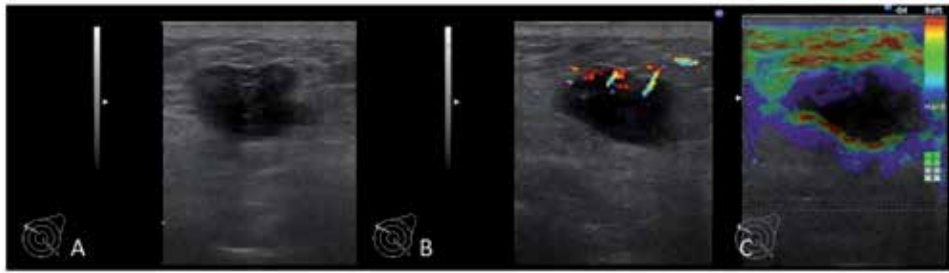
Intensely hypoechoic nodule with partially well-defined, partially ill-defined margins (A), moderately vascularized on color Doppler examination (B). The elastography displays a blue-green-red appearance (C). Core biopsy revealed an ILC lesion.
